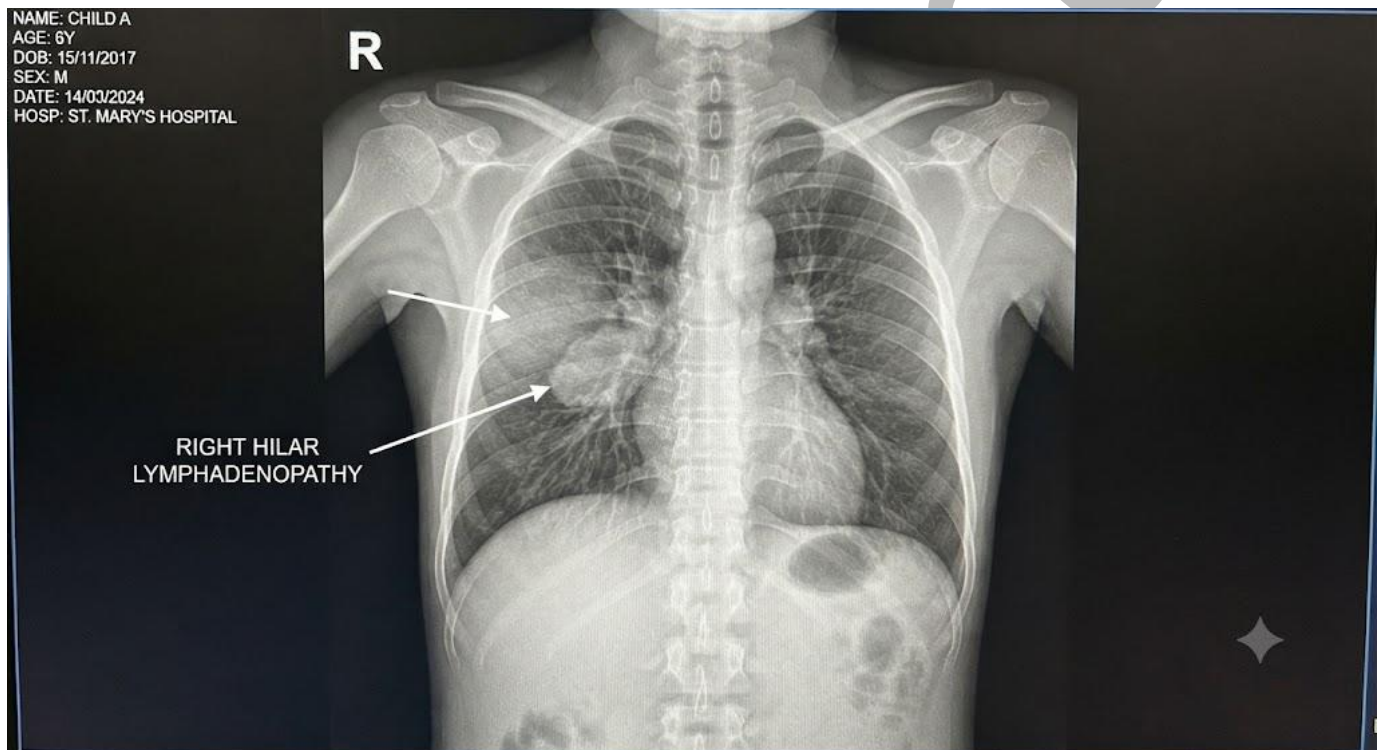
A chest radiograph showing changes consistent with primary pulmonary tuberculosis.
